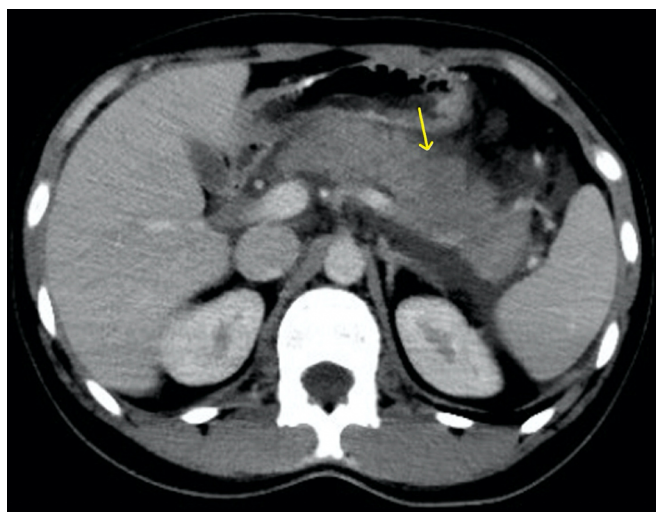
Contrast-enhanced abdominal CT demonstrates diffuse pancreatic enlargement and edema with prominent peripancreatic fat stranding and fluid collections. Heterogeneous hypodense areas at the pancreatic body–tail junction, consistent with parenchymal necrosis, are indicated by yellow arrows.
